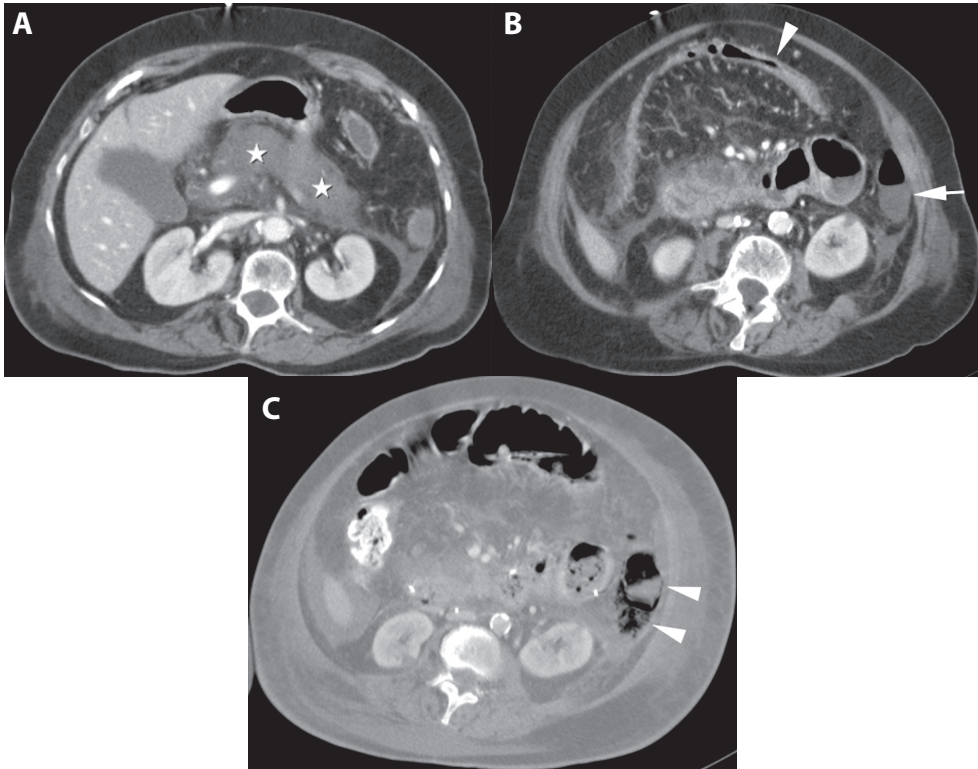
A 58-year-old woman with bowel ischemia of descending colon complicating acute necrotizing pancreatitis. (A) Contrast-enhanced CT performed on day 2 after symptom onset shows extensive necrosis of pancreatic body and tail (white stars). (B) Same CT at a lower level shows normal enhancement of the bowel wall of the transverse colon (arrowhead), while the descending colon shows absent bowel wall enhancement indicative for ischemia, which was overlooked by the radiologist. (C) Repeat contrast-enhanced CT 24h later for continuing severe sepsis depicts the development of gas in the bowel wall of the descending colon (pneumatosis intestinalis) and adjacent mesocolon (arrowheads) suggestive for bowel necrosis. Emergency laparotomy was performed which confirmed the CT findings.
